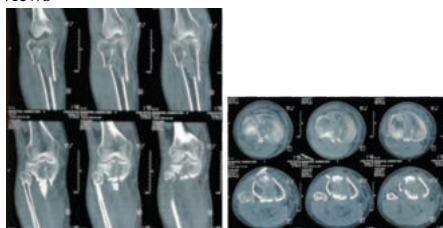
CT cuts showing fracture pattern
